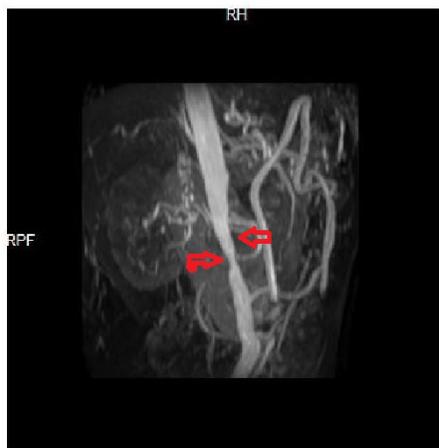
CT angiography revealed 50-60% stenosis in the aortic-wall with irregularities.
